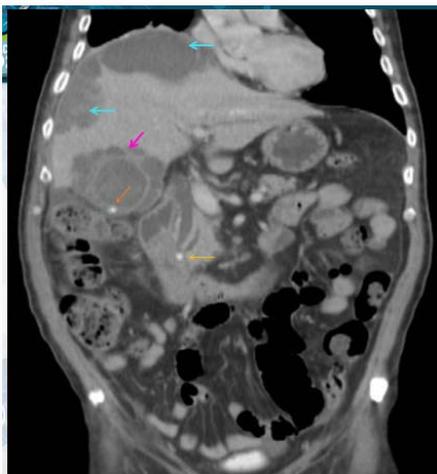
Abdomen CT before procedures showing choledocholithiasis (yellow arrow); Acute gallstone cholelithiasis (orange arrow); Intra-hepatic abscesses (blue arrows); and gallbladder perforation with surrounding collection (pink arrow).
